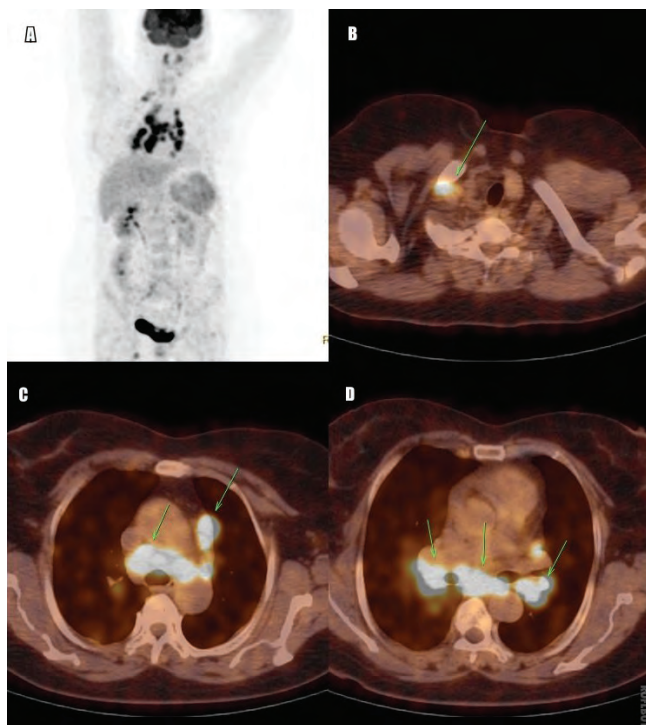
MIP image. FDG PET/CT axial images revealed intensely hypermetabolic bilateral chest lymphadenopathy in a butterfly-shaped distribution pattern, which was typically seen in patients with sarcoidosis(A). Supraclavicular and infraclavicular hypermetabolic multiple LAPs which the largest was 16 mm sized (SUDmax: 8.5) (B). Intensely hypermetabolic LAPs which the biggest was 27 mm diameter (SUDmax: 14.0) were observed in the mediastinal prevascular area, right upper and lower paratracheal, aortopulmonary, carinal, subcarinal, paraesophageal and bilateral hilar areas (C-D).
